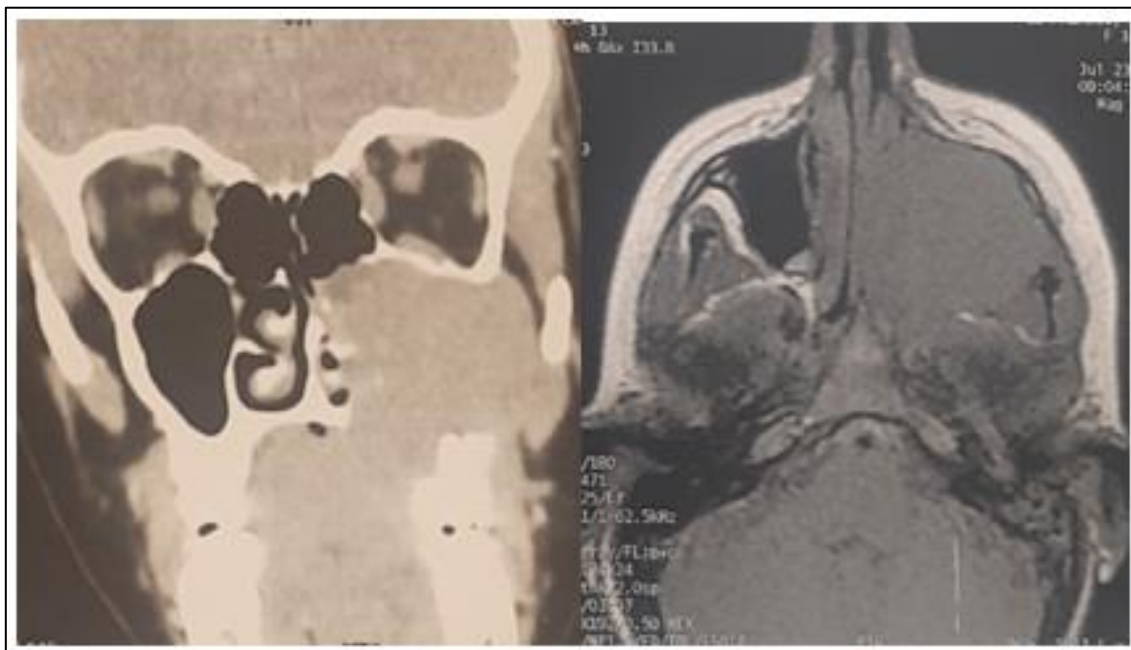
Axial / Coronal Facial CT scan images showing: a left maxillary sinus mass destroying the alveolar process
